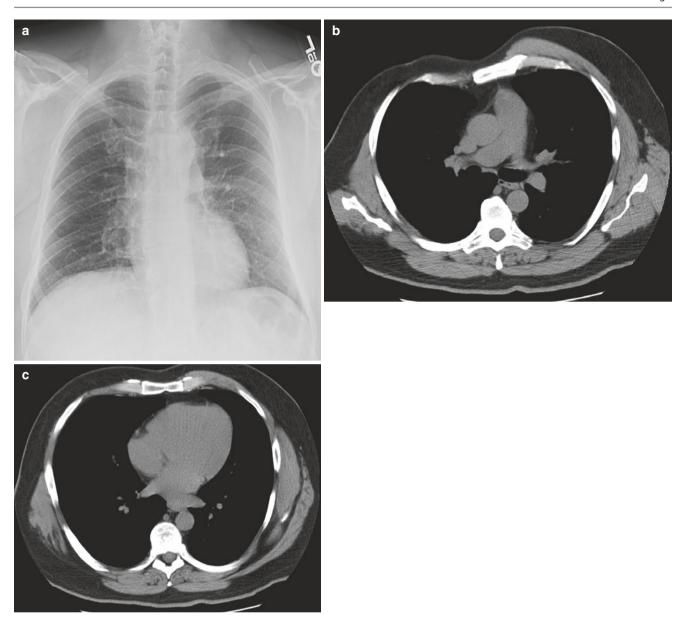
Poland syndrome. (a) Frontal radiograph shows asymmetric translucency on the right hemithorax. (b, c) Axial CT images reveal the absence of multiple right-sided chest wall muscles
